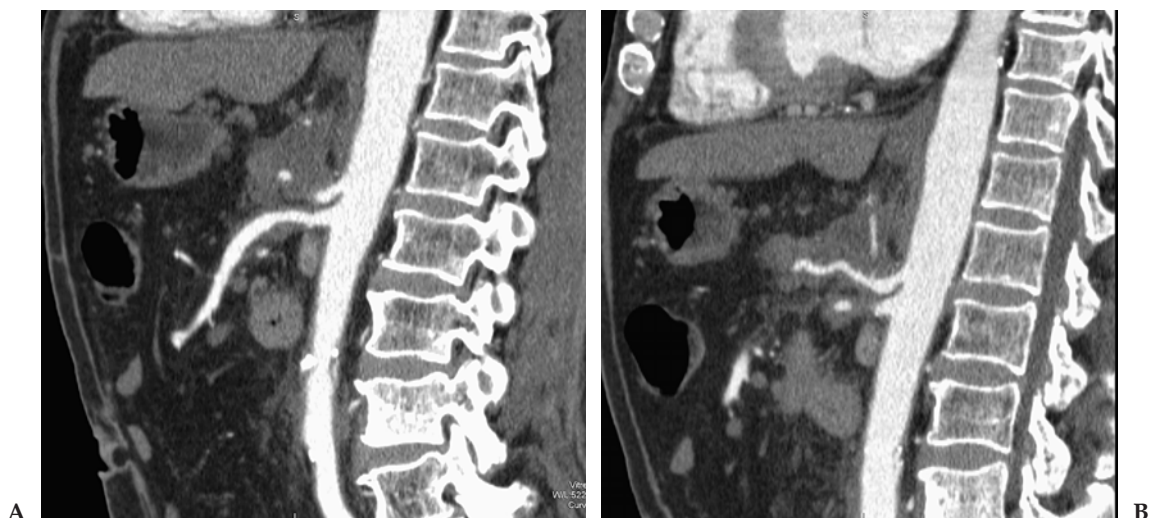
(A and B) Curved sagittal images through the SMA and celiac arteries. The curved images show the circumferential encasement of the vessels by tumor. Mild narrowing and irregularity is also present. (Courtesy of Dr. Stanley Laucks, Alpha Advanced CT, York, PA.)
